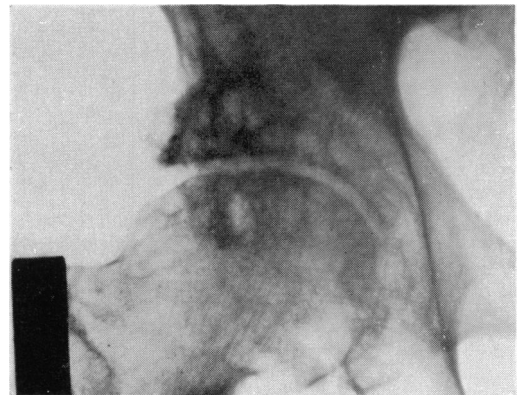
Twelve months after osteotomy. Radiographic improvement is coming to an end. The joint has been saved from collapse*
